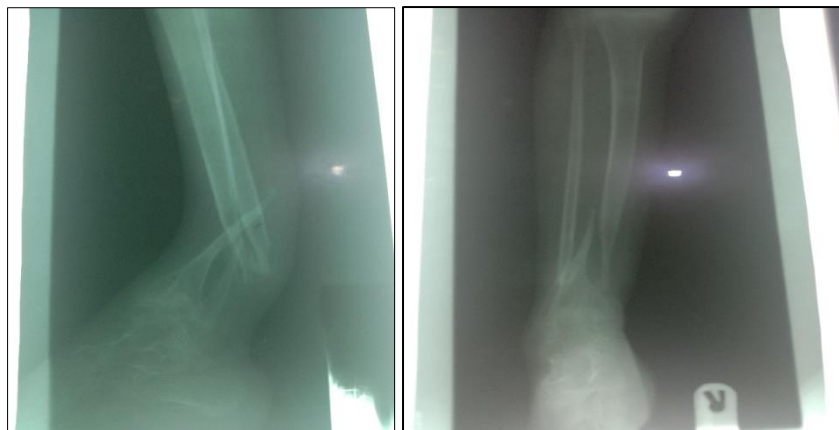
X-ray showing distal fracture of the tibia and fibula, with associated pseudoarthrosis
